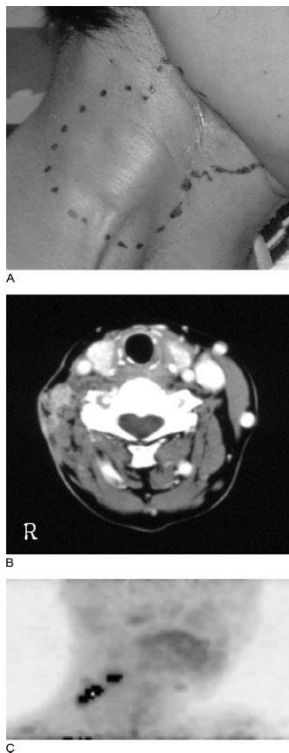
(A) Local findings before BNCT. (B) Neck CT before BNCT. (C) ^{18}F BPA PET examination where BPA uptake was measured (images reprinted with the permission of the editor, license number 2762421391809).
